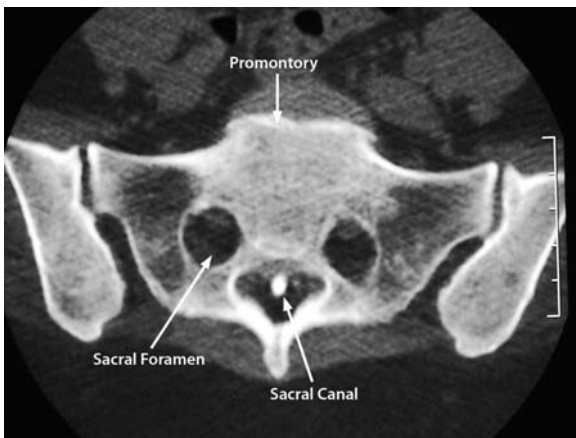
Non-enhanced axial CT image shows the sacral promontory, sacral foramen, and sacral canal
